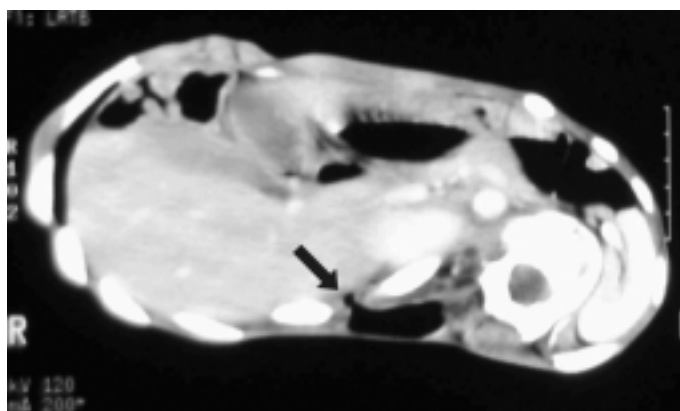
Chest computed tomography scan demonstrates a pleuro-cutaneous fistula communicating the posterior costophrenic recess and subcutaneous air pocket at the back (arrow)
